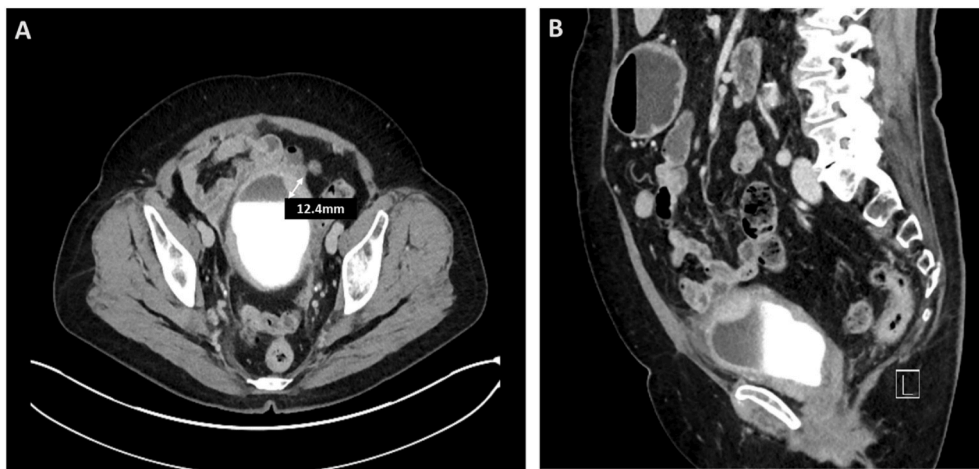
Cross sectional (panel A) and sagittal (panel B) views of CT abdomen/pelvis obtained before cyclosporine therapy demonstrating mild diffuse bladder wall thickening. There is focal increased wall thickening and enhancement in the anterior left upper aspect (white arrow, panel A) measuring over 12.4mm in thickness.
